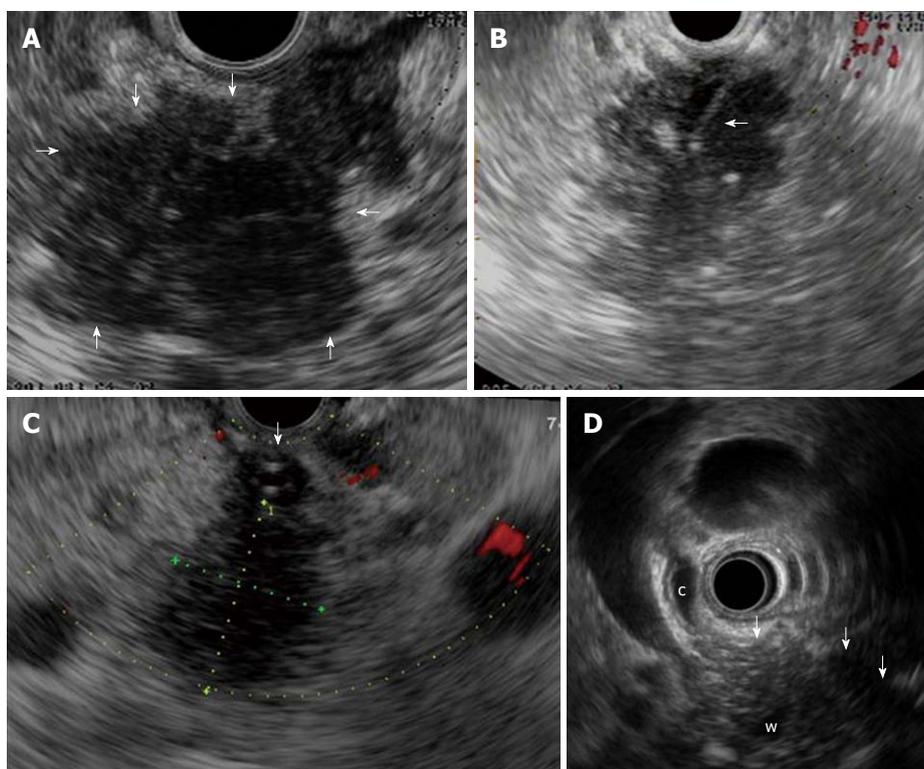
Focal form of autoimmune pancreatitis. A: Endoscopic ultrasonography (EUS) shows a focal lesion (arrows) of pancreatic head which is echopoor with hyperechoic strands; B: A EUS-guided fine needle aspiration is performed (arrow) for tissue characterization; C: Another case of focal autoimmune pancreatitis (AIP) with echopoor lesion of pancreatic head (between callipers) and marked echopoor thickening of the choledochal wall (arrow); D: In this case of focal AIP EUS shows an echopoor lesion (arrows) of pancreatic head, with upstream dilatation of both common bile duct (c) and pancreatic duct (w); notice the thickened choledochal wall.
